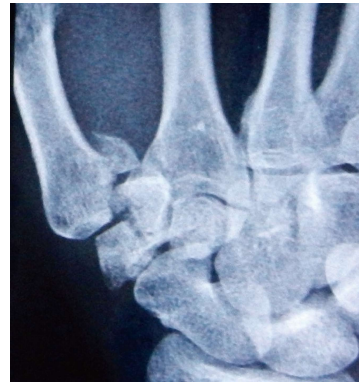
Preoperative radiograph showing the Bennett's fracture with fracture of the trapezium.
